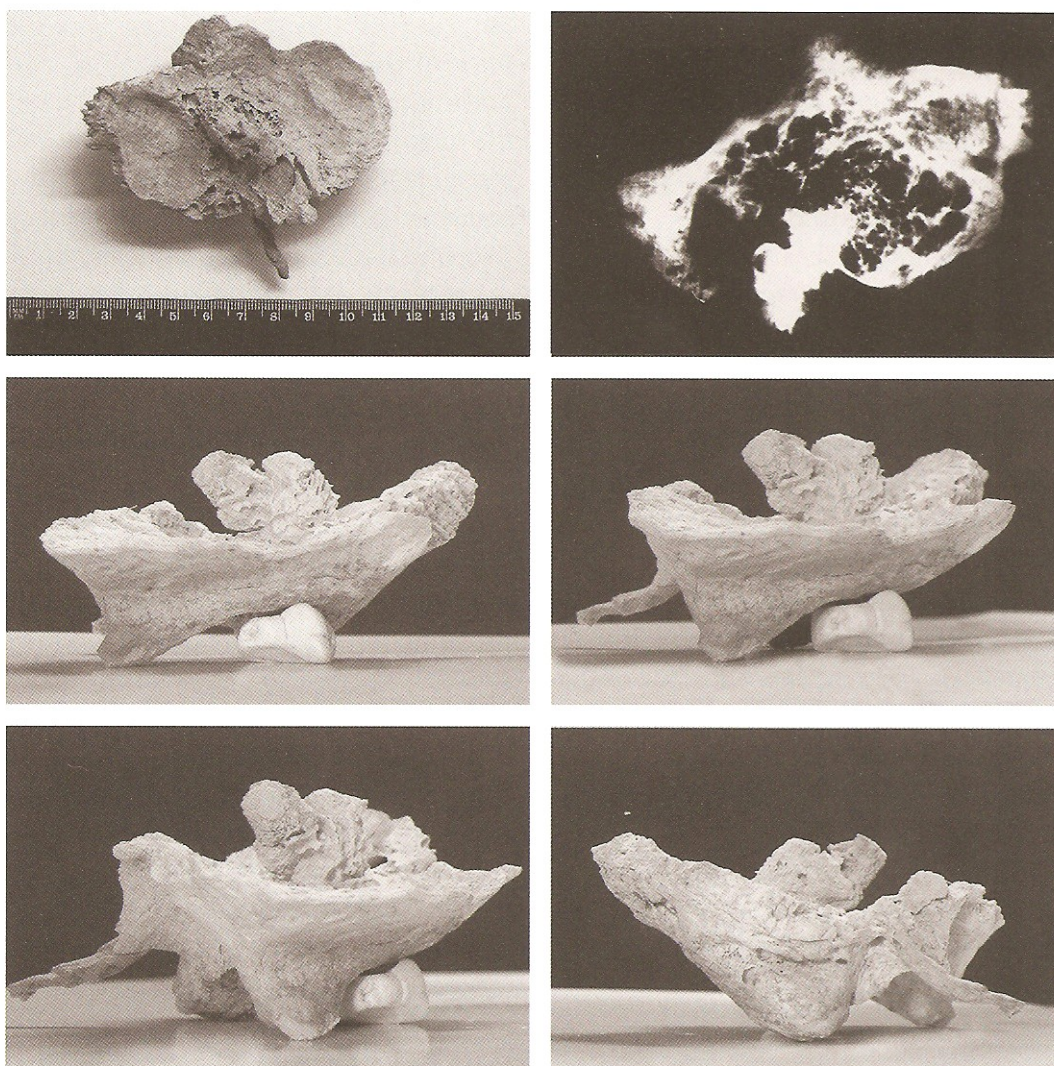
The right and left top panels, respectively, show a complete view of the internal surface of the left temporal bone and its radiograph. The middle and bottom panels show the exophytic hyperostosis from different sides.
